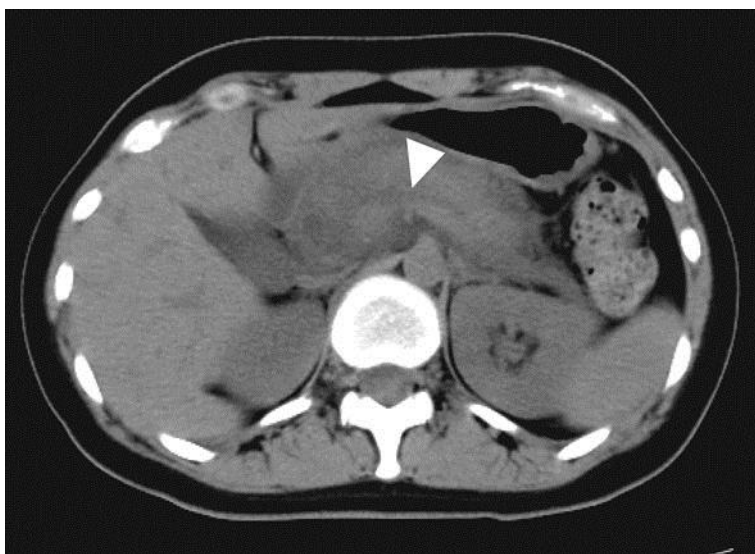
CT image from a previous hospital shows diffusely swollen pancreas and slightly dilated main pancreatic duct (arrowhead).
